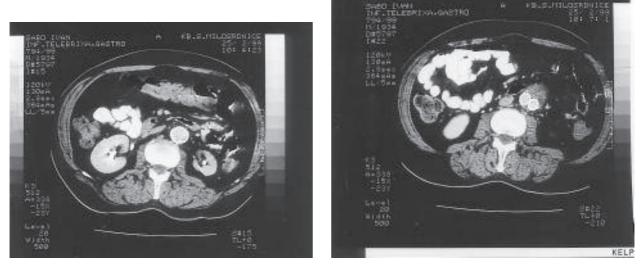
Patient 2 postoperative CT scan: right position of infrarenal and iliac prosthesis; no endoleak was observed.
